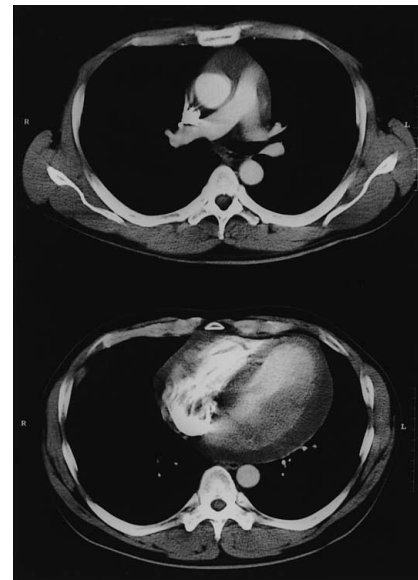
Chest computed tomography showed no abnormal lymph node swelling with the massive pericardial effusion.
